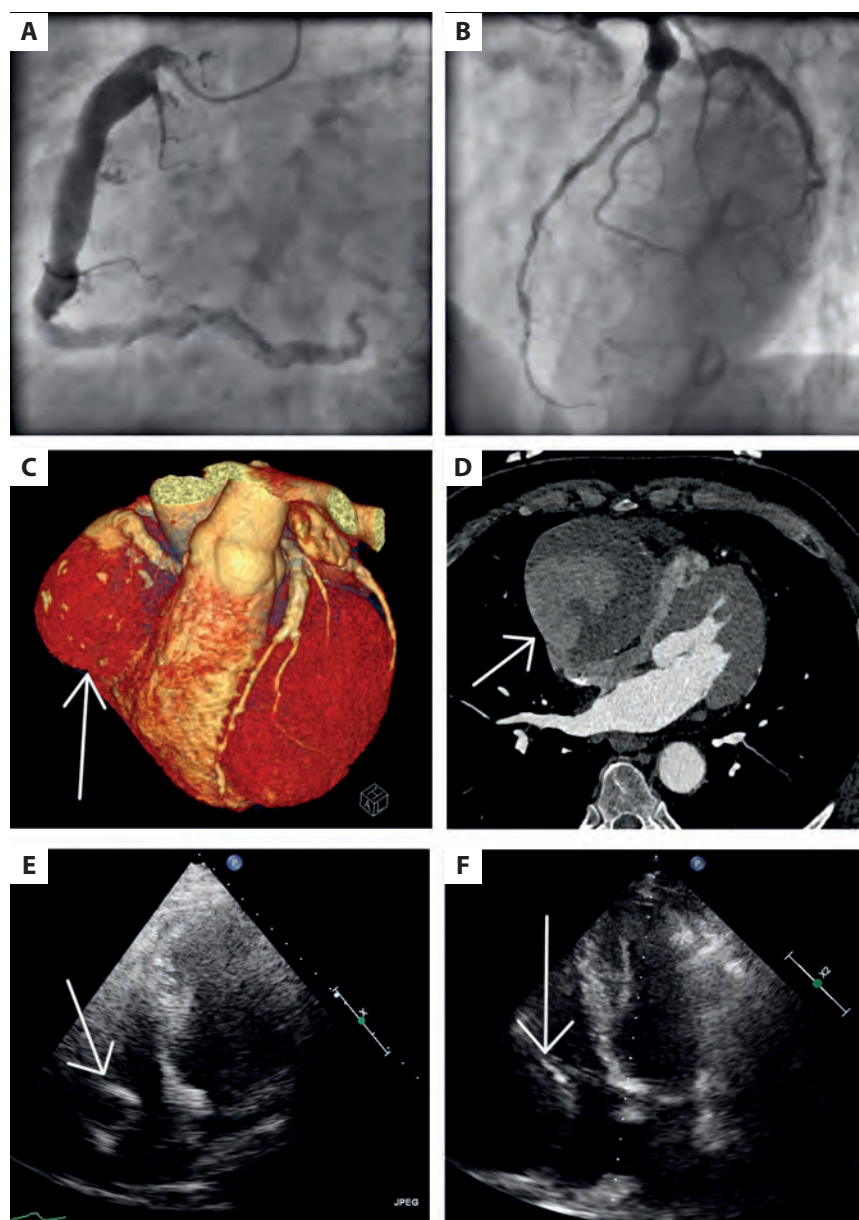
Diagnostic images of the coronary artery ectasia (CAE). A, B. The right CAE and disseminated ectasias in other vessels on initial coronary angiography. C. Digital reconstruction of the giant right CAE (arrow) based on computed tomography angiography performed immediately after diagnosis. D. Significant progression of the diameter of the giant right CAE to 86×60 mm (arrow) on the last computed tomography. E, F. The modeling of the right heart chambers by the giant ectasia (arrow) on echocardiography performed two years earlier and recently
